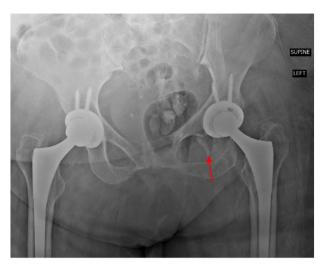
AP radiograph of the pelvis revealing a bony fragment arising from the left ischium (see arrow).
